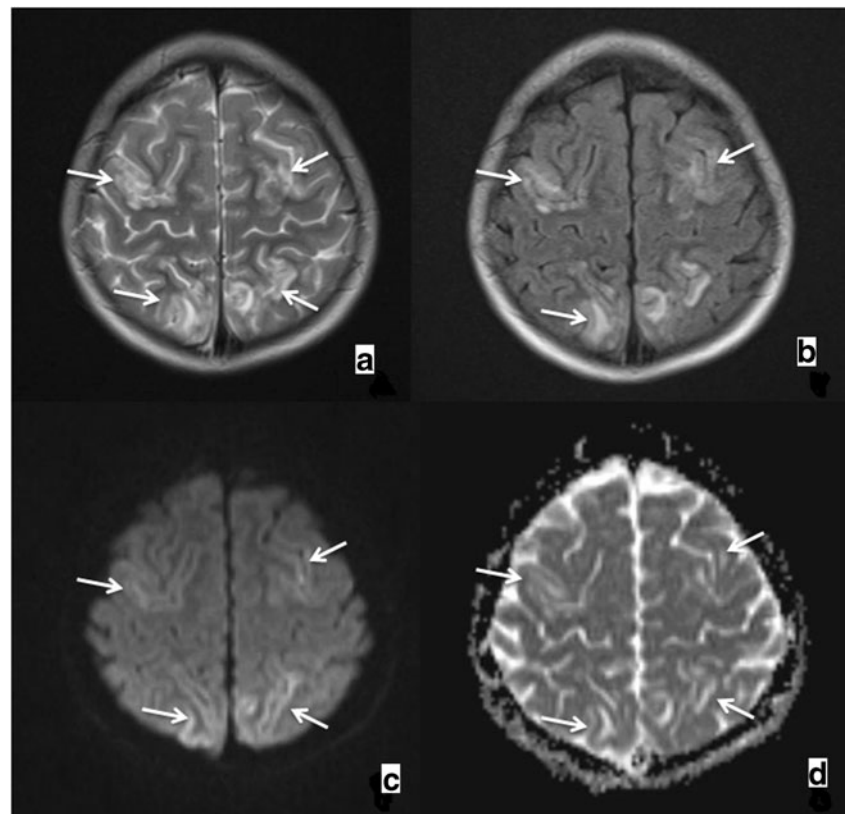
CMRI of case 2. Axial plane T2-weighted (a) and FLAIR (b) images revealed hyperintense signal changes on bilateral frontal and parietal lobes at the level of vertex. Diffusion-weighted image (c) and ADC map (d) showed an increased intensity, excluding ischemia. Findings were well correlated with PRES
